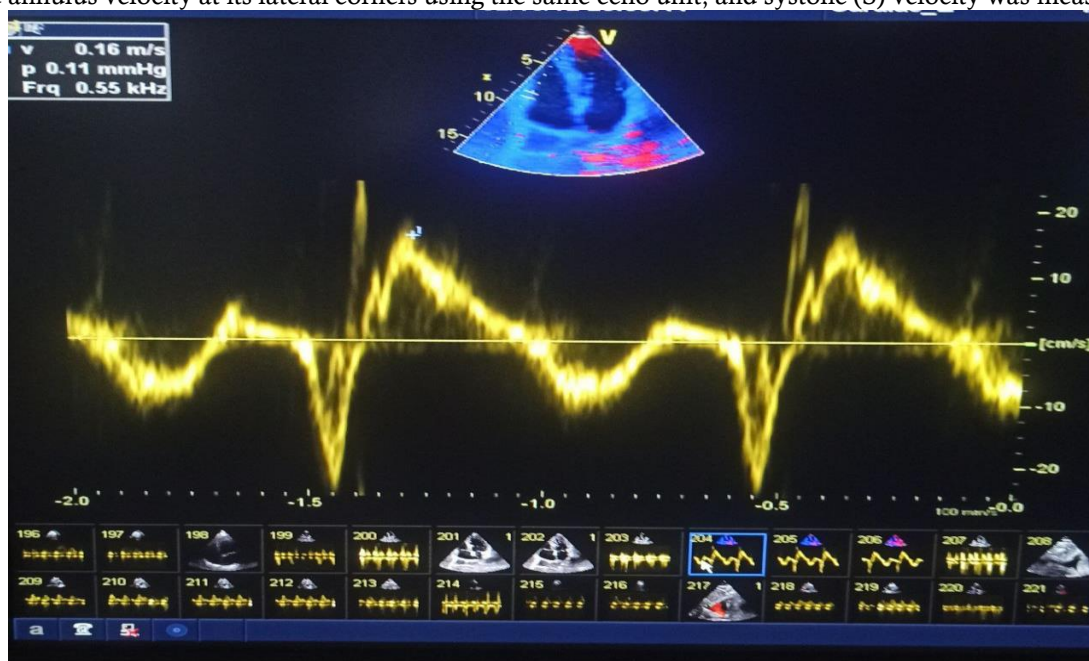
Estimation of Tissue Doppler Systolic Velocity(S') Of Rv.
